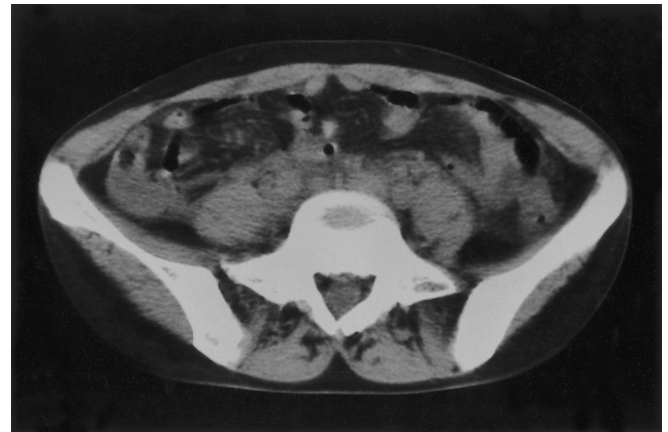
Ascites and intestinal edema in case 2 as shown on abdominal CT
